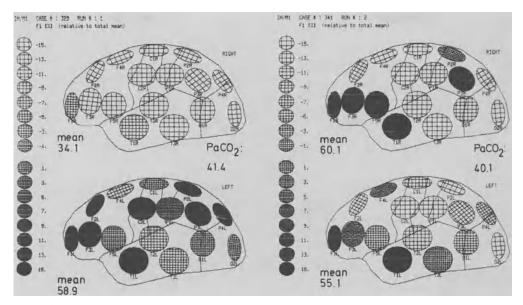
Regional cerebral blood flow in subarachnoid hemorrhage. Hemispheres on the *left* of the figure indicate relative distribution of flow on day 5 after hemorrhage; hemispheres on the *right* indicate flow distribution 6 days later, after therapy with nimodipine. Vasospasm was demonstrated by angiography and controlled by transcranial Doppler sonography. From day 5 to day 11 blood flow in the right hemisphere increased from 34.1 to 60.1 (ml/100 g/min) (upper hemispheres, *left* and *right* of figure). Mean flow in the left sides of the brain (*lower hemispheres* in the figure) did not change significantly but the territory of the middle cerebral artery presented with flow reduction after nimodipine therapy. A rebleeding had not occurred.
